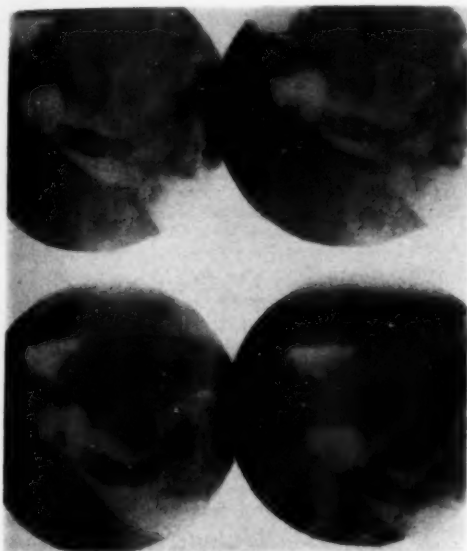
Case VIII. Male aged 60. X-ray diagnostic problem.
